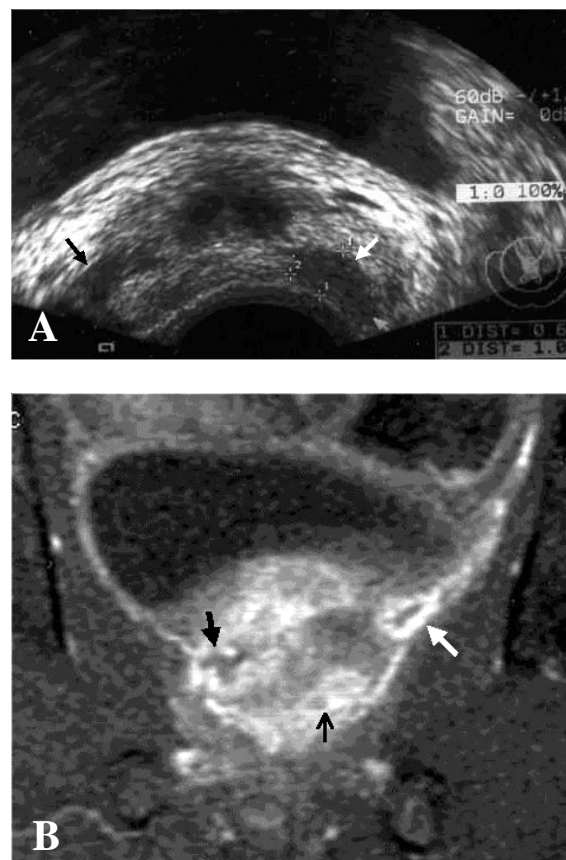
HIV-positive patient (31 years old) (A) TRUS, multiple poor-defined hypo-echoic lesions in right CG (black arrow) and left PG (white arrow) (B) MRI, coronal T1-weighted FSE, enhanced thickened wall abscess in right CG (black arrow) and left PG (thin black arrow) with enhanced periprostatic tissue, noted small abscess at left periprostatic tissue (white arrow), near to bladder neck
